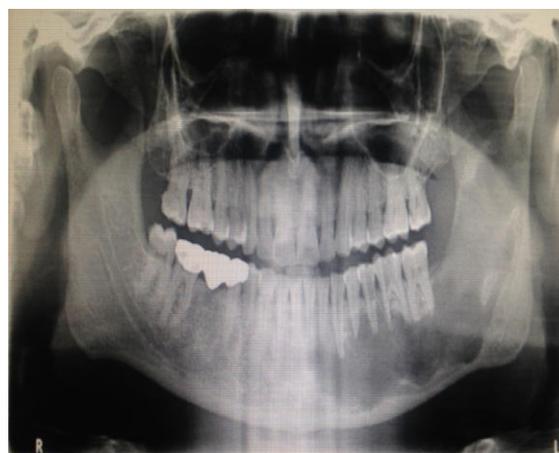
Panoramic radiograph showing extensive multilocular radiolucent lesion involving the periapical region of 31 upto ramus and sigmoid notch region on the left side
